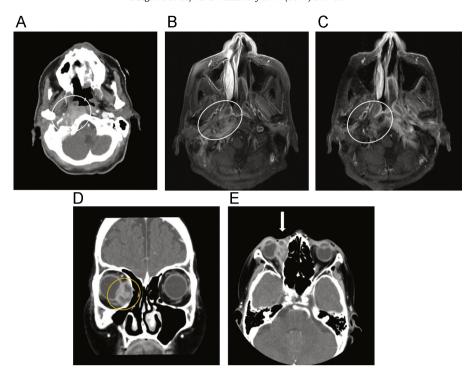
CT and MRI scans. (A) CT scan of case 1 showed an enhanced lesion from the nasopharynx to the parapharyngeal space of the right side with temporal bone destruction. (B) Contrast-enhanced T1-weighted MRI showed homogeneous enhancement of the lesion. (C) Enhanced MRI 5 months after prednisolone was started. The lesion had significantly decreased in size. (D, E) Axial (D) and coronal (E) CT scans of case 2 revealed a well-defined, 3.5 × 2 cm mass in the right orbit. (F) Axial CT scan revealed the mass was slightly decreased in size.
